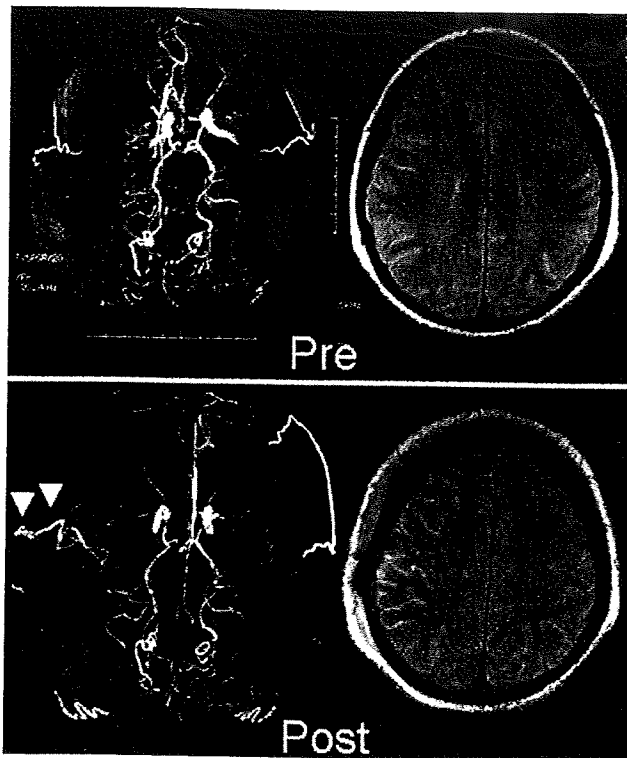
Upper Left: Preoperative MR angiogram. Upper Right: Preoperative FLAIR study. Lower Left: Postoperative MR angiogram showing the apparently patent STA-MCA bypass (arrowheads). Lower Right: Postoperative FLAIR study showing high intensity signal around the site of anastomosis.
